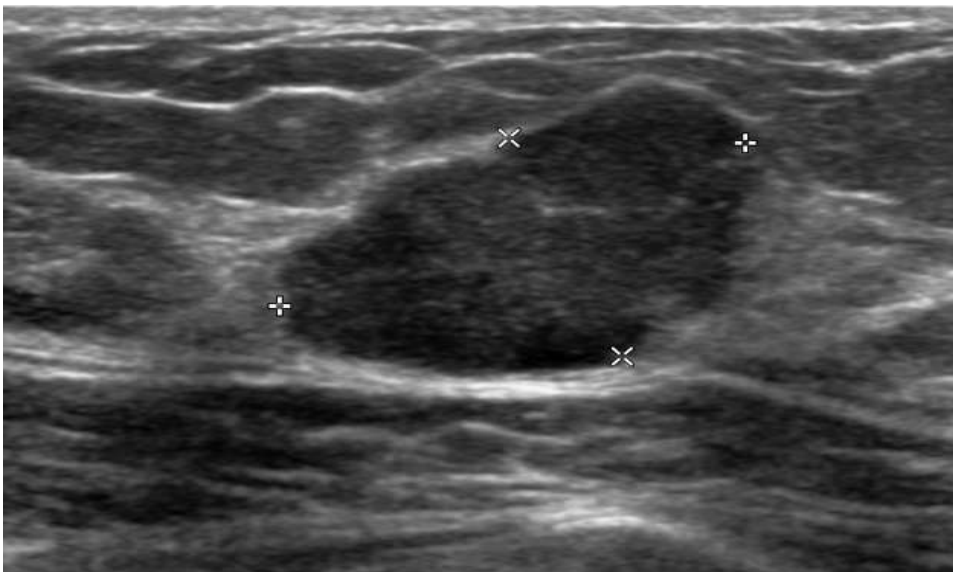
Ultrasound image of infiltrative ductal carcinoma . hypoechoic irregular outline breast mass in a 20 years old patient .
